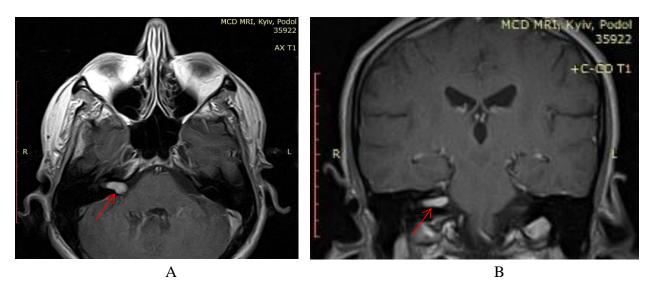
T1 MRI images with contrast, with full occupancy of the IAC and dilation in the medial portion near the CPA – trumpet sign: A - axial projection; B - coronal projection.
